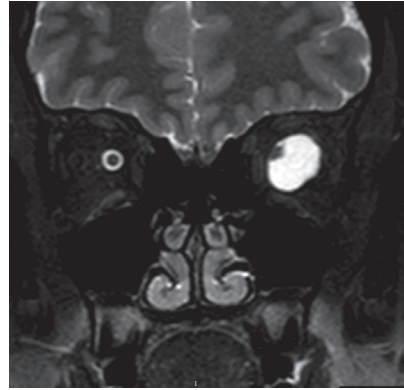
Postoperative coronal MRI with contrast scan of the patient.
